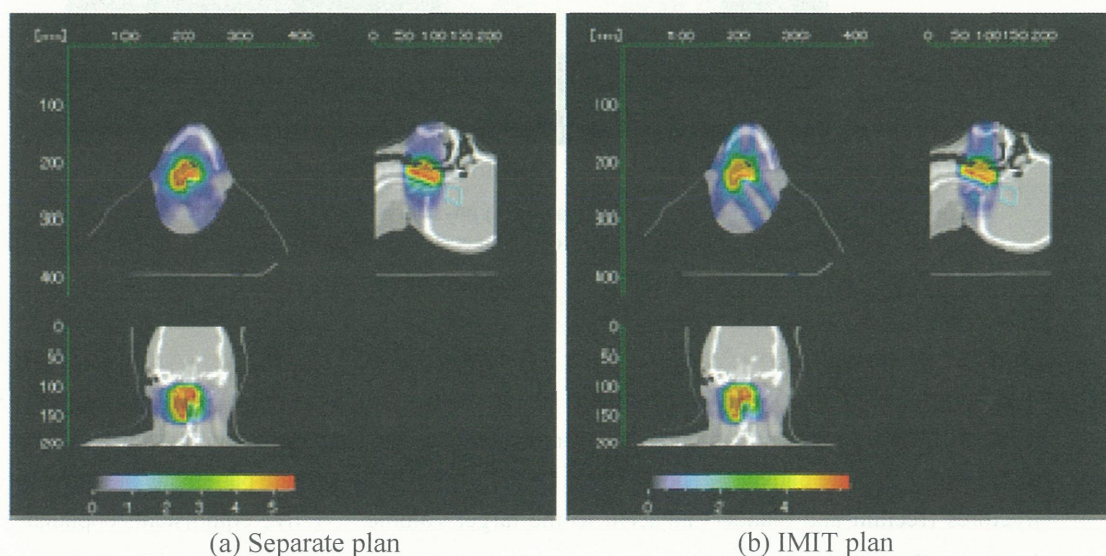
CT images of the cervical chordoma patient with color-wash biological dose display . The yellow line outlines the PTV and the watery lines delineate the OARs (spinal cord and brain stem). A five equidistant, coplanar beam setup was chosen during planning.
